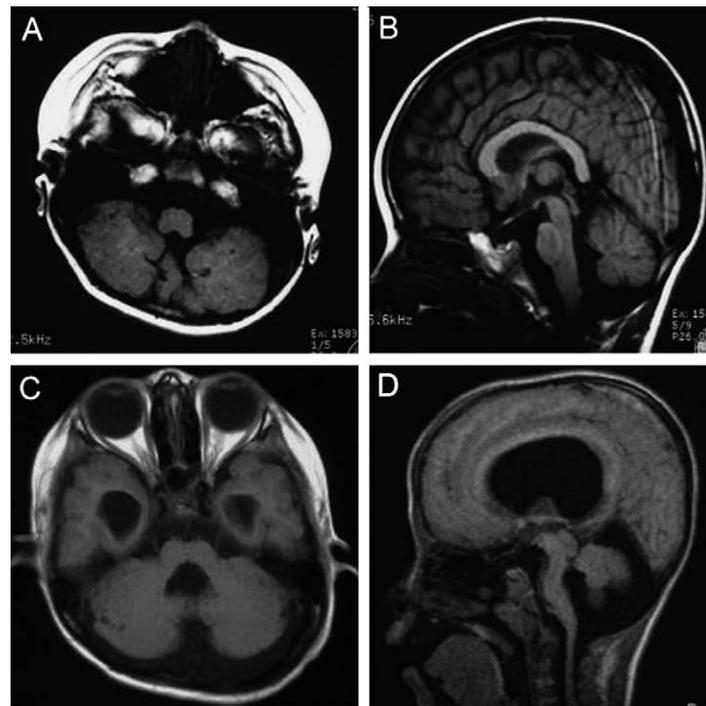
Brain MRI of patient 1 (A and B) and patient 2 (C and D). T1 weighed images of patient 1 show multiple cerebellar cysts and dysmorphic cortical structures in bilateral cerebellar hemisphere (A). No abnormal findings are seen in cerebrum and brain stem (B). T1 weighed images of patient 2 show multiple cerebellar cysts (C), atrophic brain stem and markedly dilated lateral and third ventricles (D). Typical type II lissencephaly was seen in cerebrum (data not shown).
